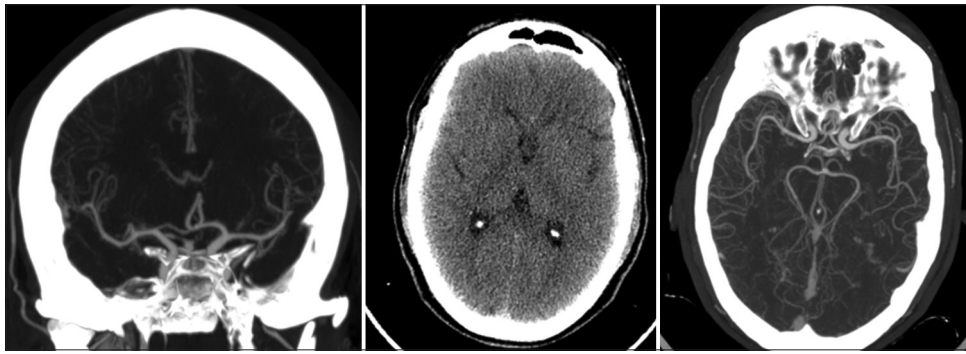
Computed tomography cerebral angiography demonstrating normal intracranial arterial circulation without evidence of vasculitis, aneurysm, or vascular malformation
